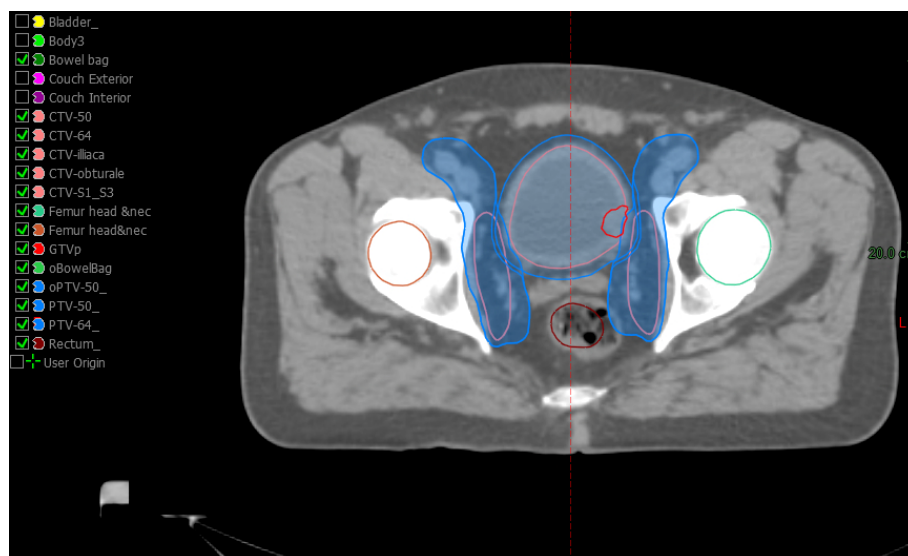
Transverse CT image slice with delineated GTV, CTV, PTV and organs at risk in a muscle invasive bladder cancer patient including lymph nodes in the treating site.*
